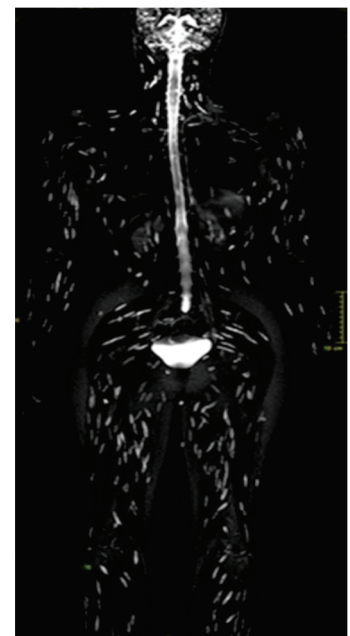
2 A whole body MRI image showing the typical rice grain like lesions all over the body-typical 'starrysky' appearance seen in disseminated Cysticercosis.
